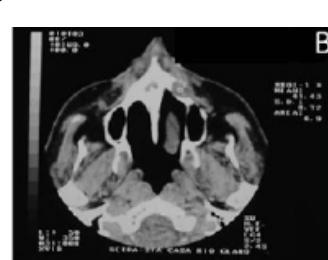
CT scan axial view showing osteolytic lesion located.
